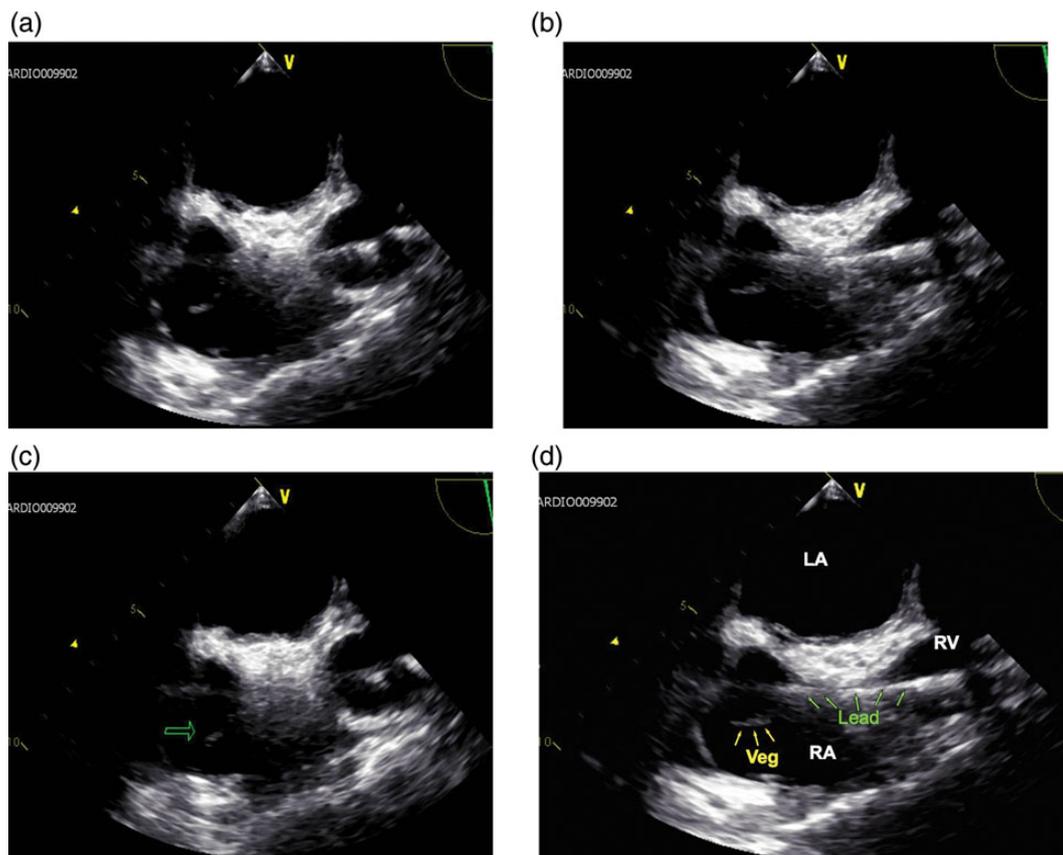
(a–d) Transoesophageal echocardiogram images which show a hypoechoic linear structure which represents the vegetation and not a loop of the pacemaker lead, which would be hyperechoic. The vegetation is attached to the atrial segment of the pacemaker lead and is distant from other heart structures. The vegetation is indicated with an arrow in (c) and is labelled in (d).
